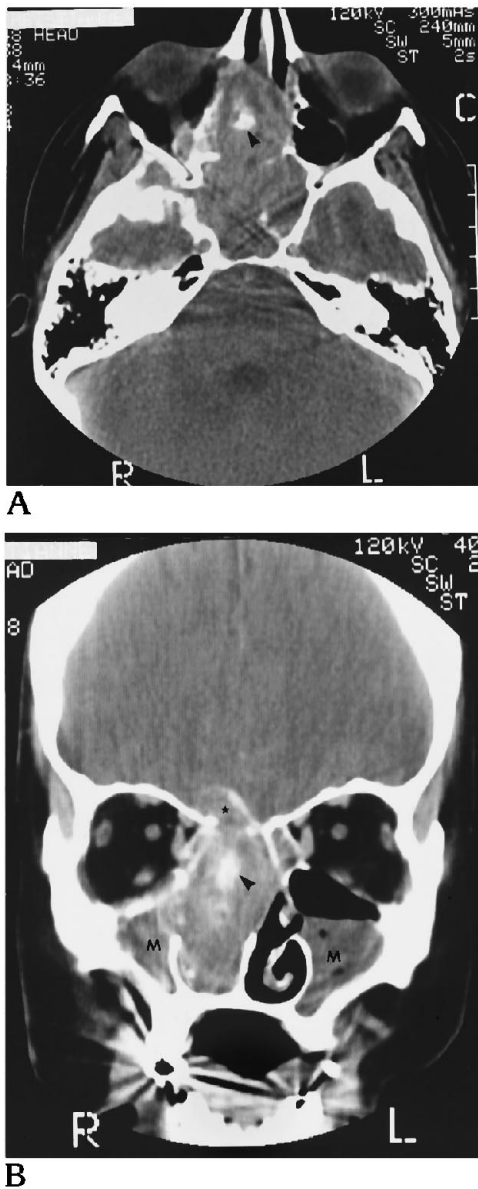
Axial (A) and coronal (B) computed tomographic scans show a nasal and nasopharyngeal soft-tissue mass with calcification (*arrowhead*) invading into the anterior fossa (*star*). Maxillary sinus disease is again seen (*M*) (Elscent 2400, Exel, Haifa, Israel).
